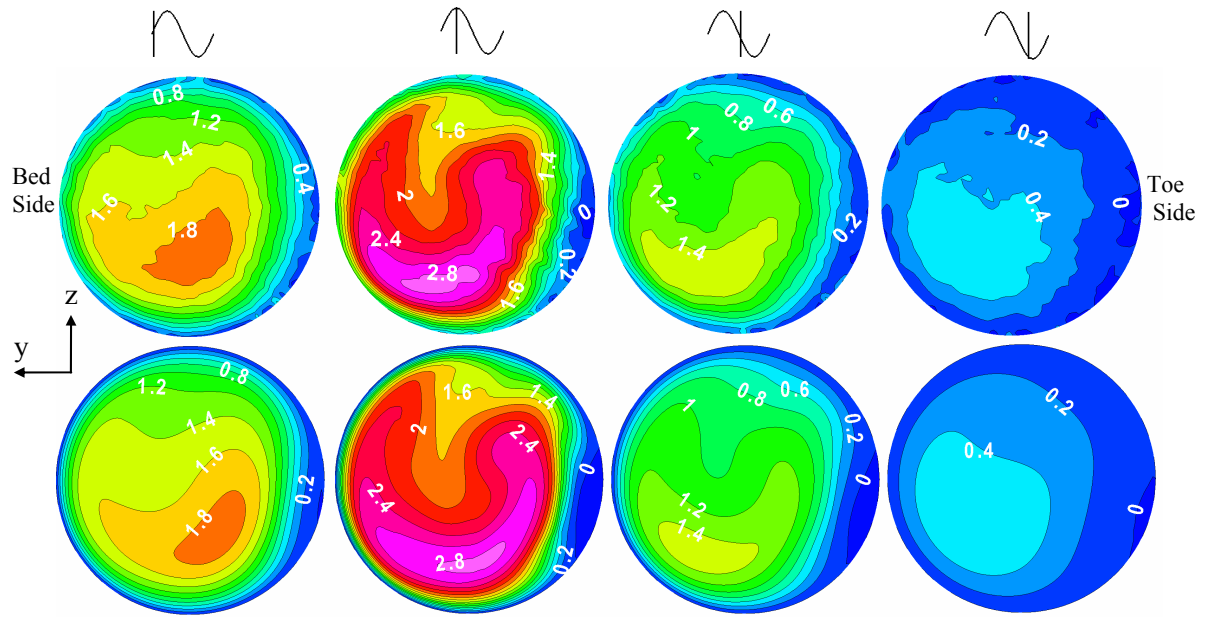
Comparison of MRI measured (top) and numerically computed (bottom) axial velocity, normalized by mean flow rate per unit area, at $0.25D$ downstream of the toe and (from left to right) at approximately mid acceleration, peak flow, mid deceleration and late deceleration in the non-planar geometry. Cross sections plotted with bed wall on the left and toe wall on the right.
